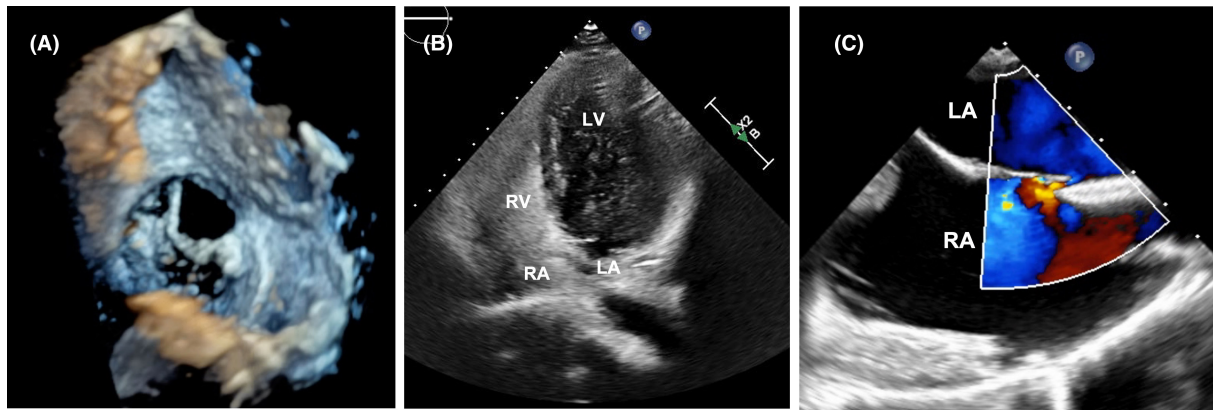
Echocardiography showing atrial abnormalities (A: father; B, C: son). LA, left atrium; LV, left ventricle; RA, right atrium; RV, right ventricle.
